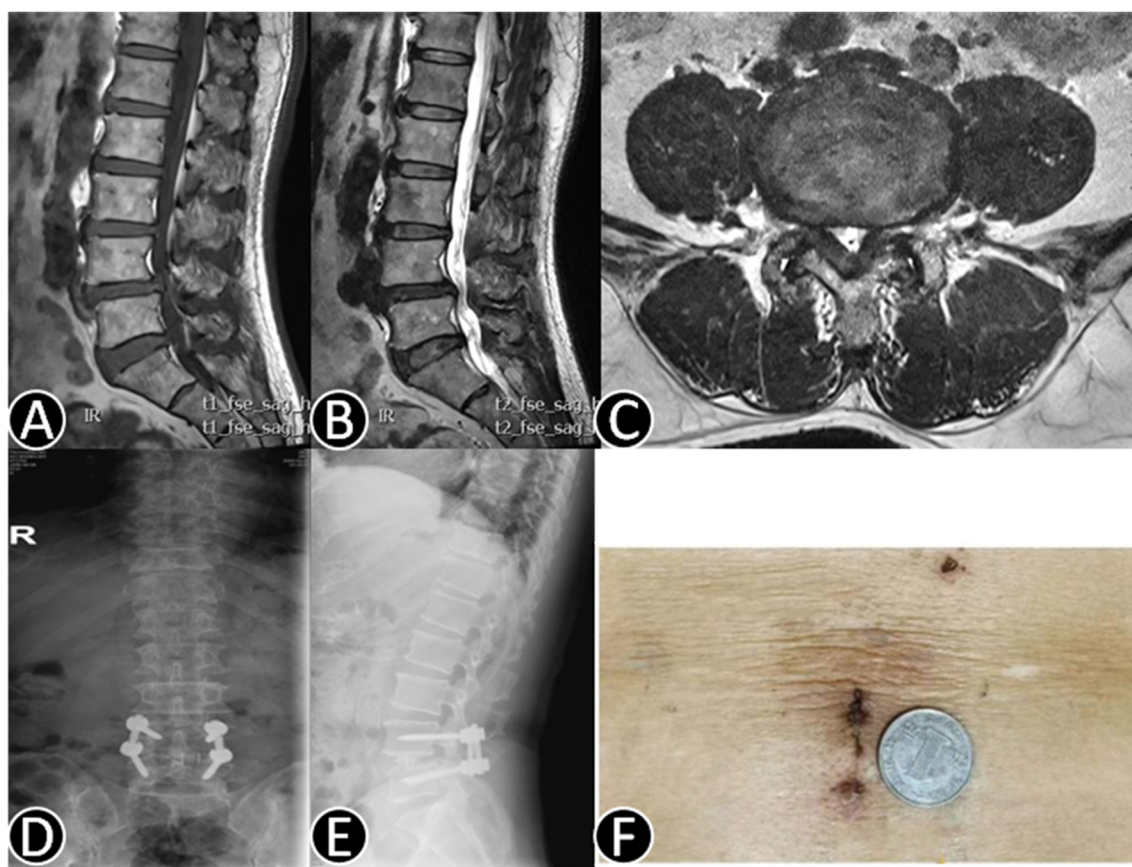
A 71-year-old male patient with low back pain and left leg pain. (A) Sagittal T1-weighted, (B) sagittal, and (C) axial T2-weighted MRI of a patient with severe L4–5 lumbar stenosis. (D, E) X-ray films after surgery. (F) Mini-open incision to accomplish minimally invasive transforaminal lumbar interbody fusion (Mis-TLIF).
